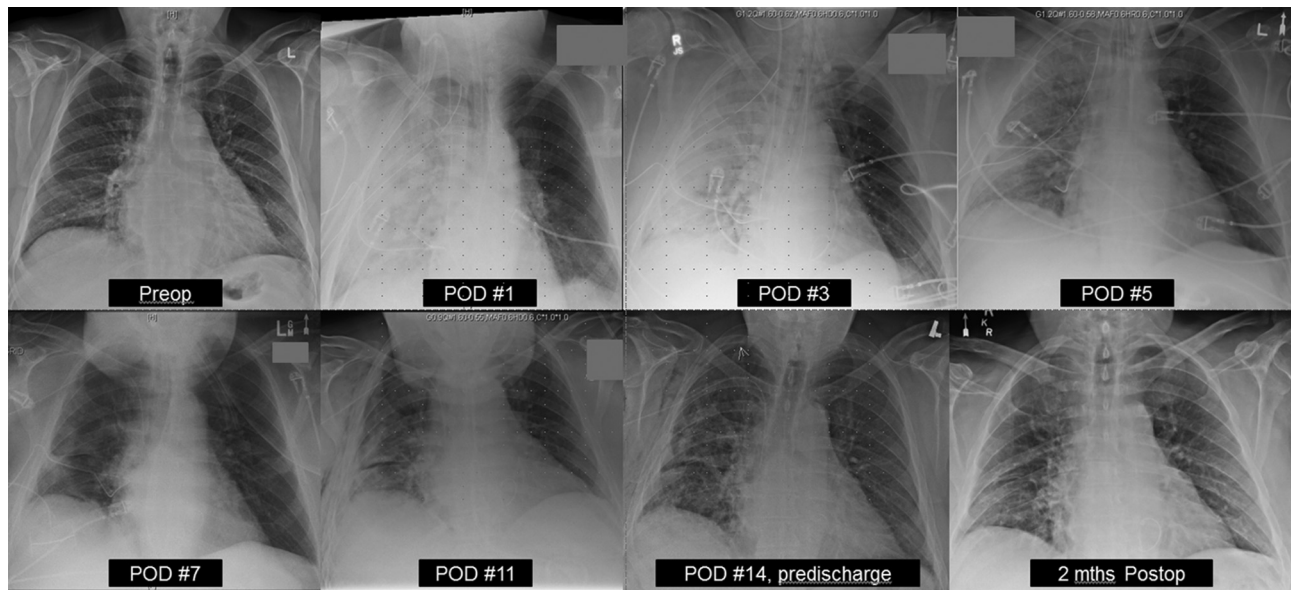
Serial chest radiographs of a 67-year-old patient with moderate chronic obstructive pulmonary disease, significant pulmonary hypertension (right ventricular systolic pressure: 76/22 mm Hg), and obesity who underwent a minimally invasive mitral valve repair for Barlow's disease. He experienced acute, unilateral, postoperative pulmonary edema shortly after returning to the intensive care unit. The serial chest radiographs demonstrate significant right lung opacification between the first and third postoperative days, with interval resolution thereafter. (Preop = preoperative; POD = postoperative day.)
